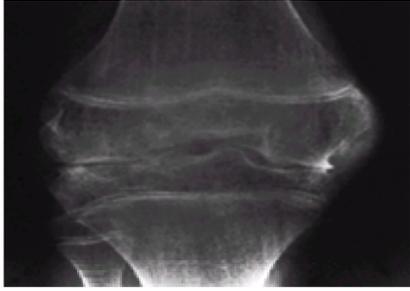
Radiograph of the knee of a 14-year-old boy with advanced hemophilic arthropathy.
